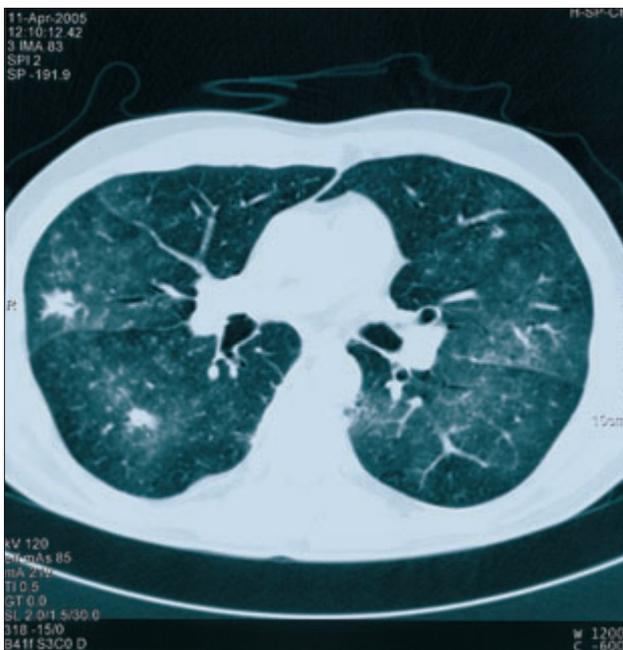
CT picture of “milk-glass” by interstitial pneumonia before therapy.
